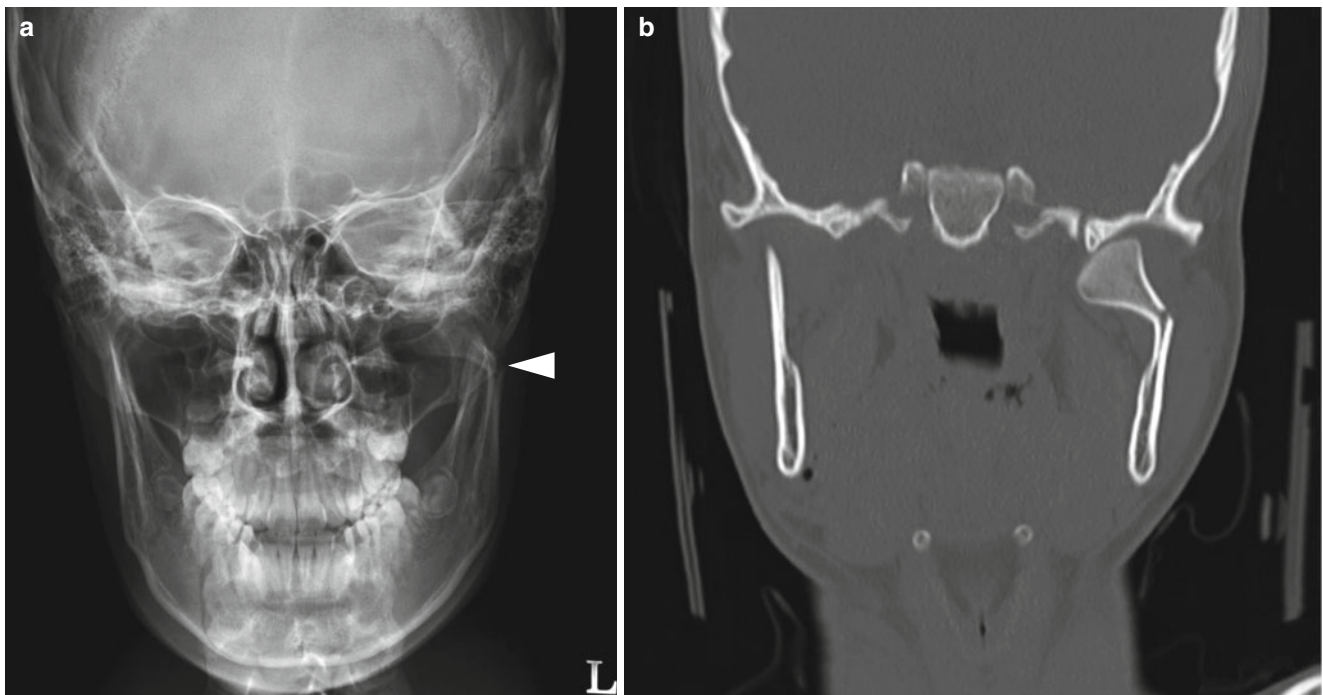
Mandible condylar fracture. (a) Skull PA radiograph shows angulated left mandibular condyle (*arrowhead*) suggesting a fracture. (b) Coronal reformatted CT clearly shows left condylar neck fracture
